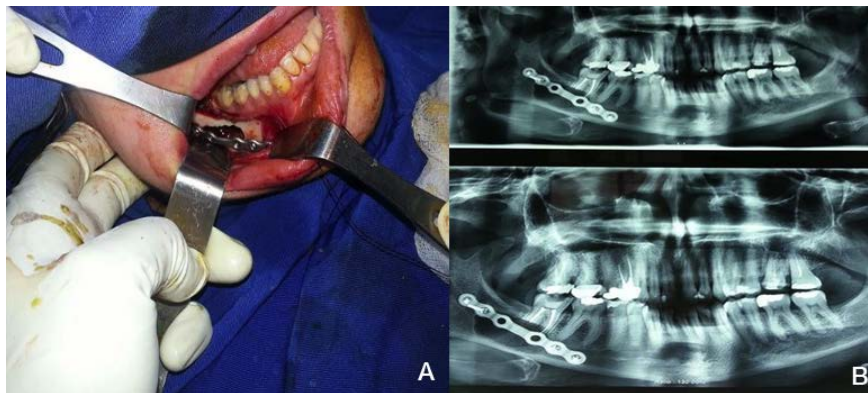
A) Intraoperative insertion of a plate with 4 screws (after removal of the cystic mass) to prevent any possible fracture of the mandible. B) Postoperative X-ray.
